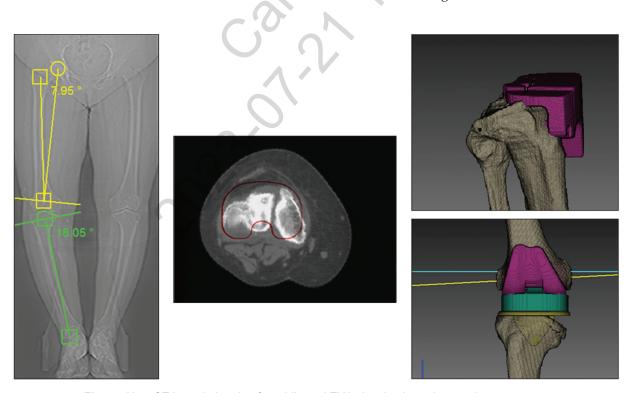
CT-based planning for a bilateral TKA showing bone loss and severe varus
